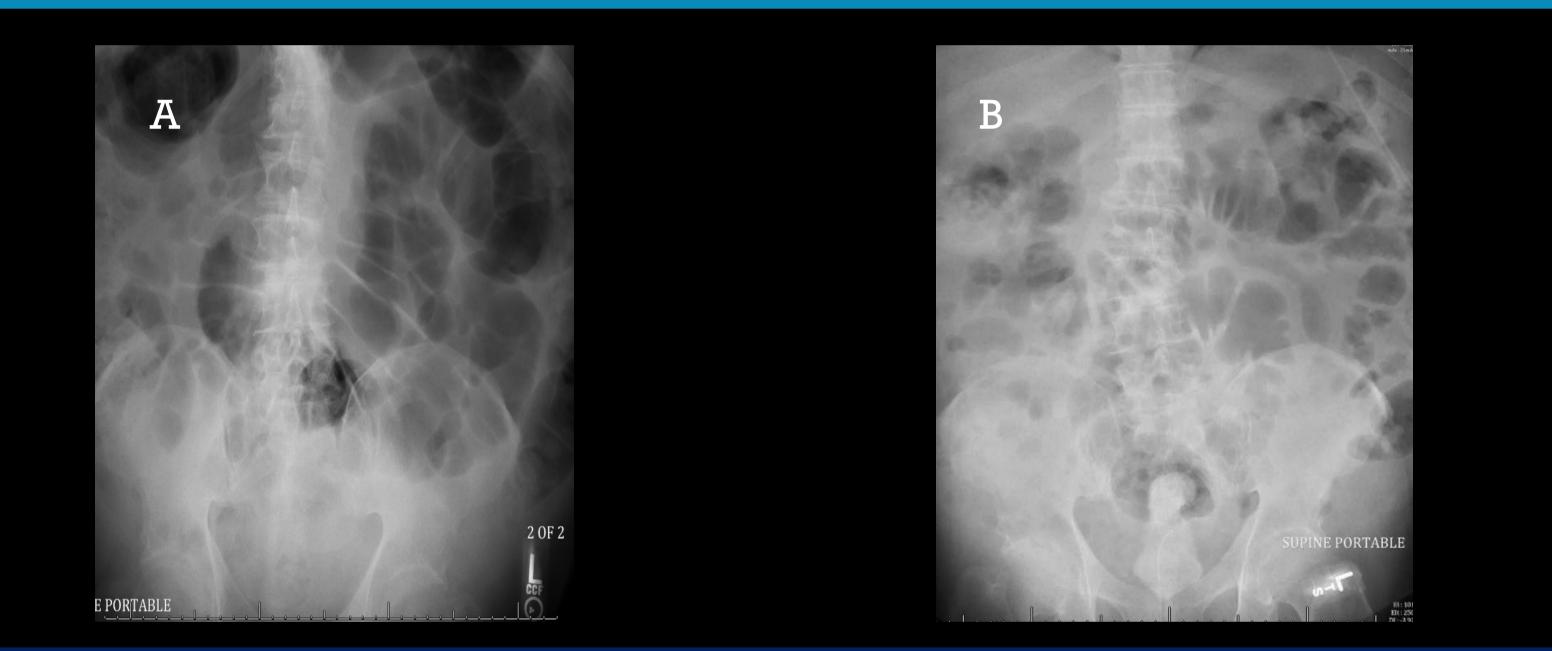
Abdominal X-ray A. Paucity of gas in rectosigmoid region concerning for large bowel obstruction. B. Gas present within the small bowel and colon with no fluid level or extraluminal gas identified on portable supine exam
